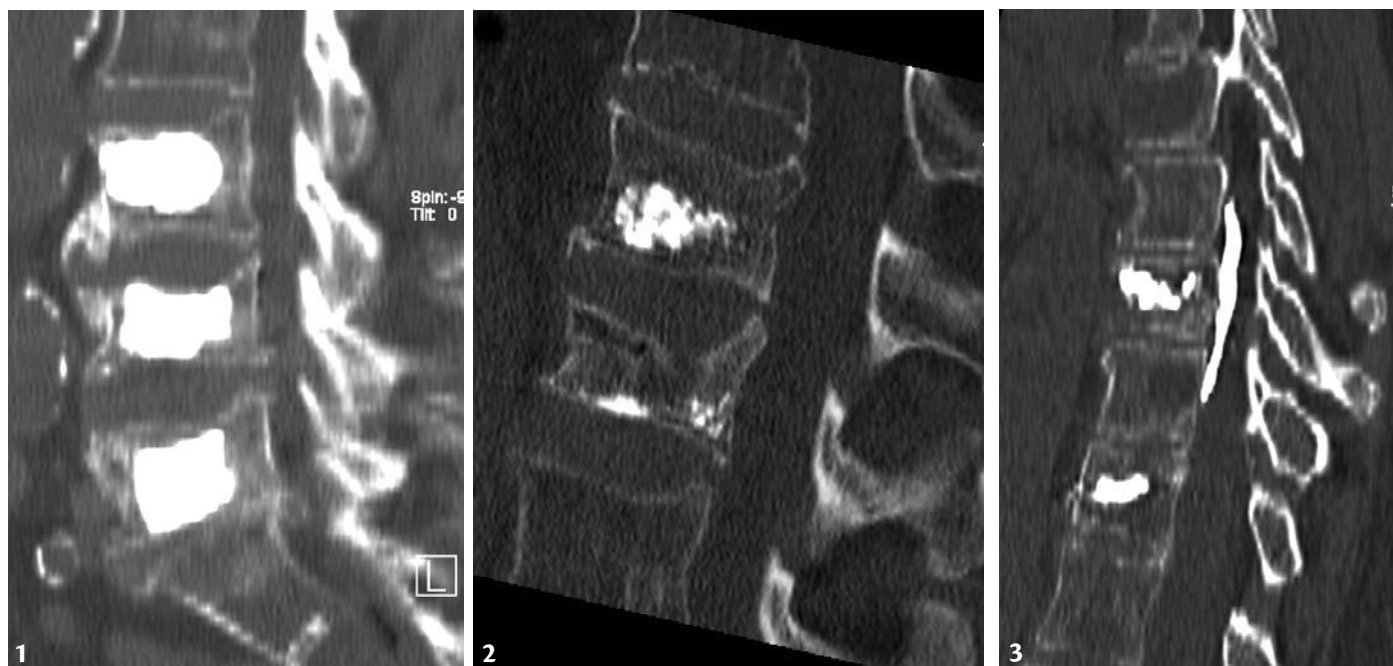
shows a VCF postop sagittal CT of a patient who had been admitted for intractable back pain. Despite bracing, physical therapy and IV pain medications, he was unable to ambulate. He was ambulatory the same day after a 40-minute, three-level VBA performed under local anesthesia. At two-week follow-up, he had weaned himself from all pain medications. Of course, this procedure does not meet CMS guidelines for VBA in that he had not had 4-6 weeks of nonoperative management. Figure 2 represents a
